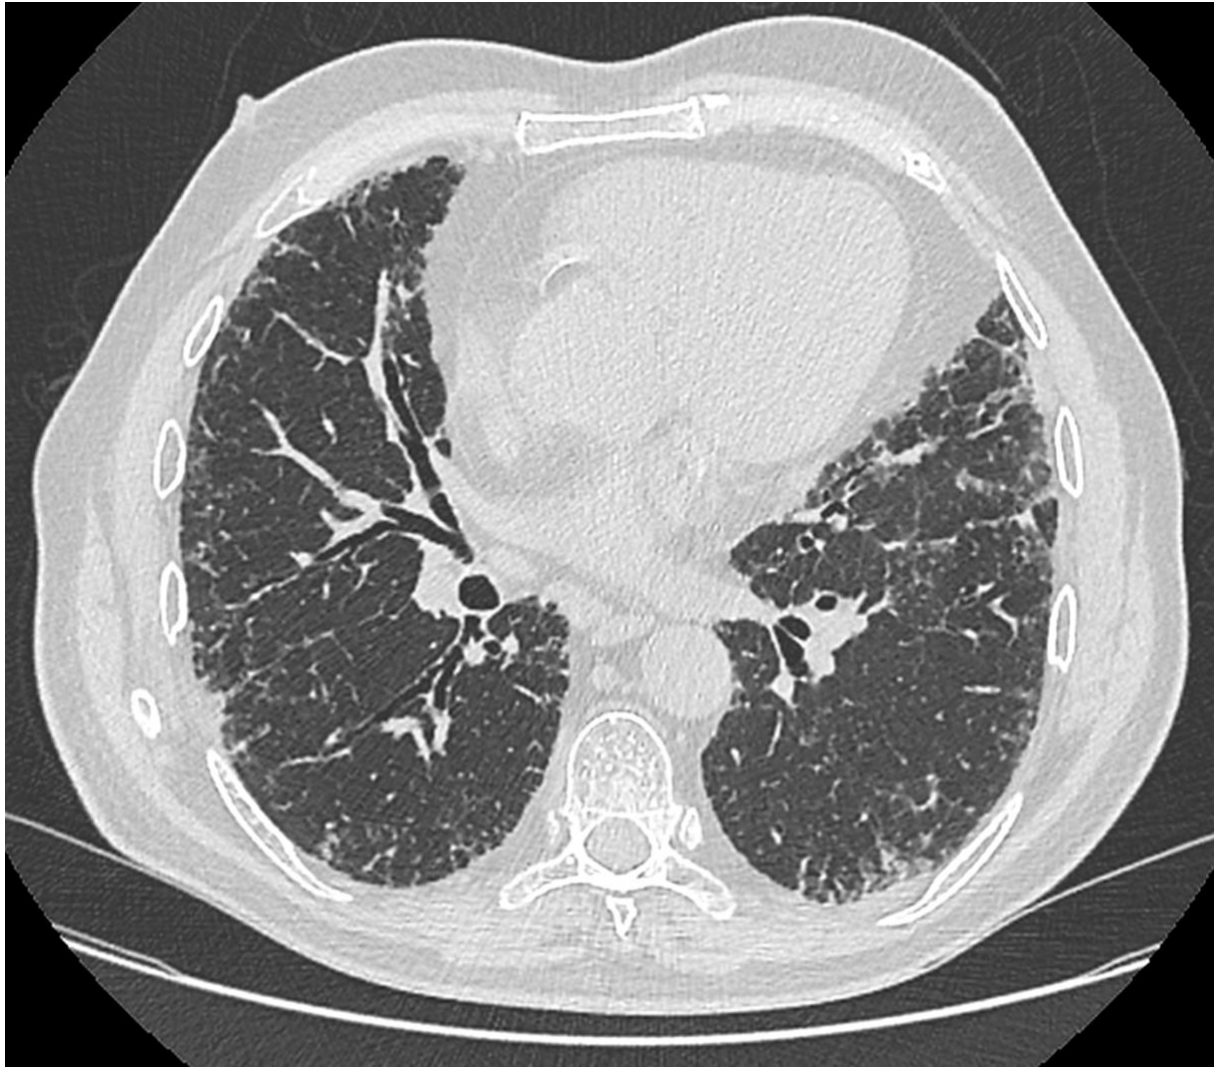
Probable UIP pattern on HRCT showing subpleural reticulation and traction bronchiectasis without honeycombing. UIP: usual interstitial pneumonia
